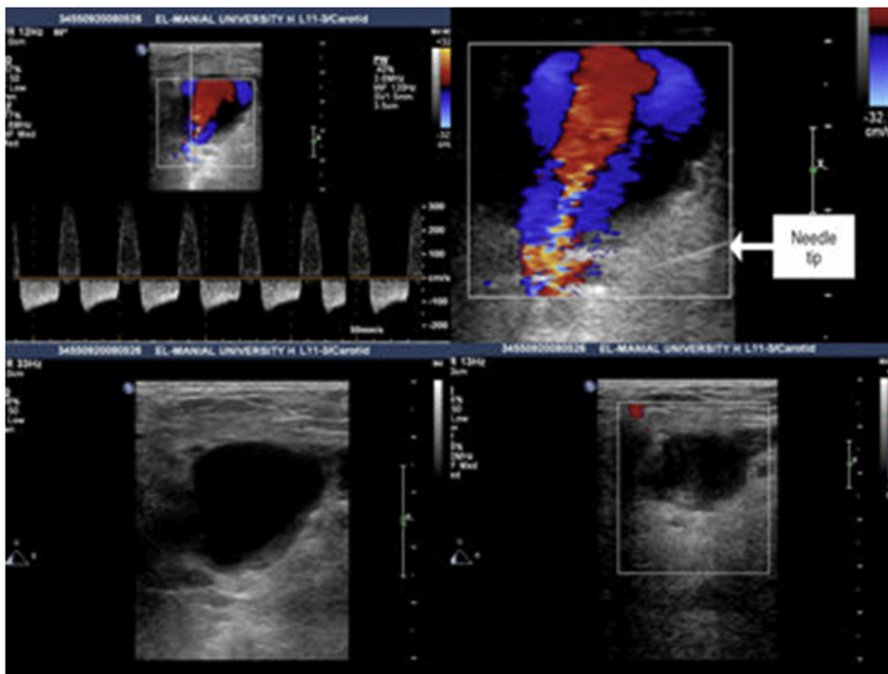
Para-aneurysmal saline injection. (A) the classic to-and-fro Doppler waveform in the neck of the aneurysm; (B) the shadow of the needle close to the neck of the aneurysm; (C) gray-scale ultrasound showing the aneurysm cavity after saline injection; (D) absent color flow in the cavity after successful obliteration of the neck.
